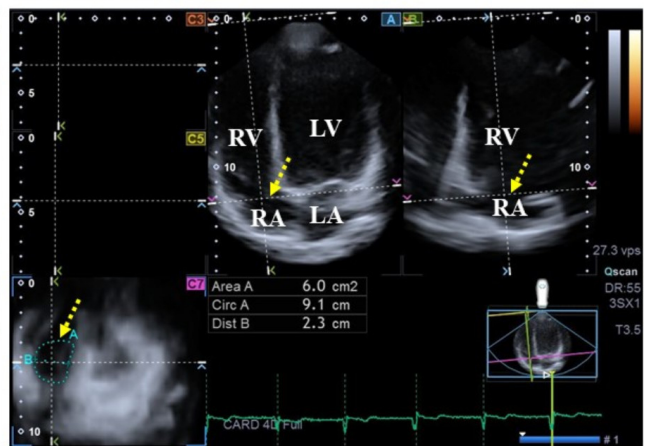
Three-dimensional (3D) speckle-tracking echocardiography-based analysis of mitral and tricuspid valve annuli. (A) Apical four-chamber long-axis view; (B) apical two-chamber long-axis view; and (C7) cross-sectional views of valvular annuli, of which their determination long-axis views helped to define and optimally select. The yellow arrow represents the mitral annulus, while the yellow dotted arrow represents the tricuspid annulus. Area: mitral/tricuspid annular area; Circ: mitral/tricuspid annular perimeter; Dist: mitral/tricuspid annular diameter. LA: left atrium; LV: left ventricle; RA: right atrium; RV: right ventricle.
